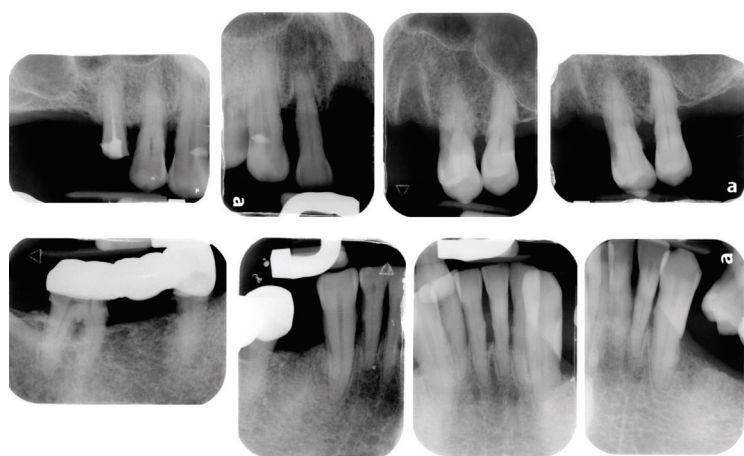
Periapical radiographic films showed unfavorable crown/root ratio for the remaining natural teeth and a poorly fitted 45-X-47 metal bridge
